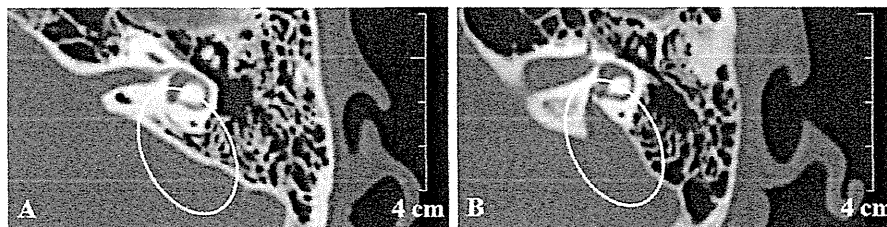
Computed tomography of the temporal bone showing an enlarged vestibular aqueduct. Circles show the vestibular aqueduct. The vestibular aqueduct is not identified in control subject (A). The enlarged vestibular aqueduct is identified in a patient with EVA (B).
